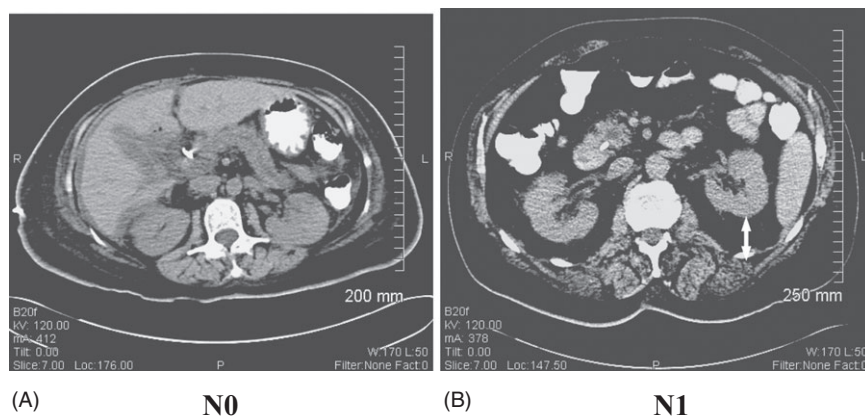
Typical computed tomography scans in (A) a node-negative (N0) and (B) a node-positive (N1) patient. The N0 patient has essentially no visceral fat pad, but the N1 patient has an approximately 3-cm fat pad
